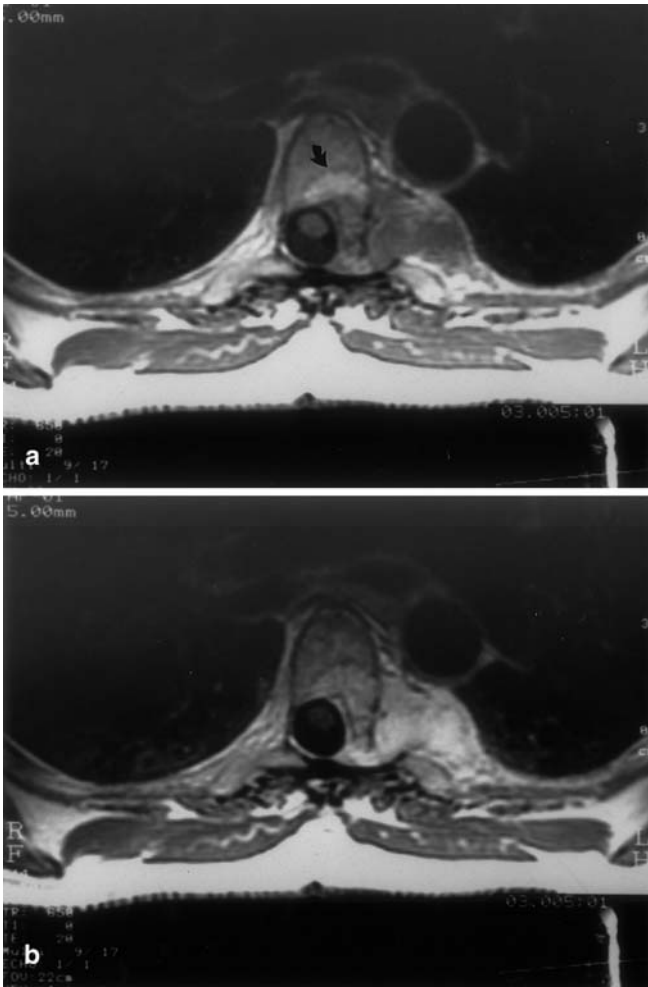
Vertebral hemangioma with paraspinal soft tissue mass. a Axial T1-weighted image shows the characteristic high signal intensity of hemangioma in the posterior part of the thoracic vertebra (*arrow*). Note also the paraspinal mass with intraspinal–extradural extension. b Axial T1-weighted image after the administration of paramagnetic agent shows intense homogeneous enhancement of the posterior part of the vertebral body as well as of the paraspinal mass
